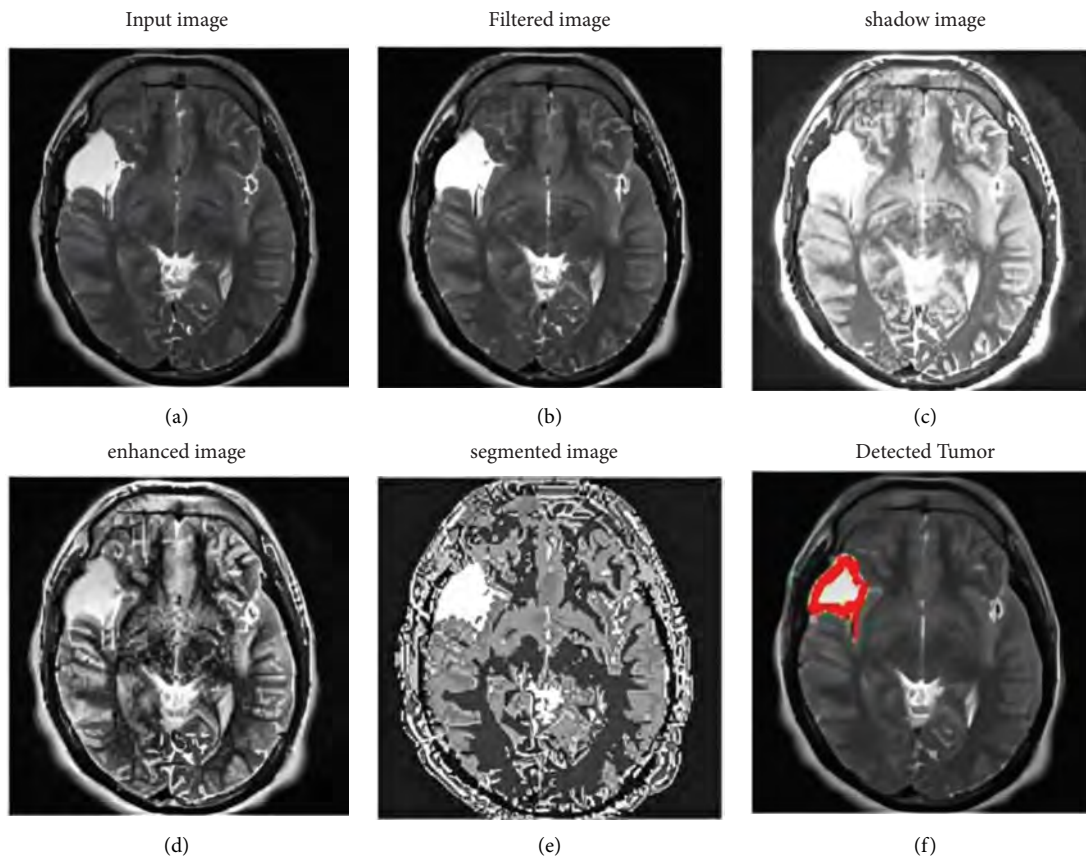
Stages in preprocessing of MRI images: (a) original image, (b) filtered image, (c) shadow image, (d) enhanced image, (e) segmented image, and (f) detected image [26].
